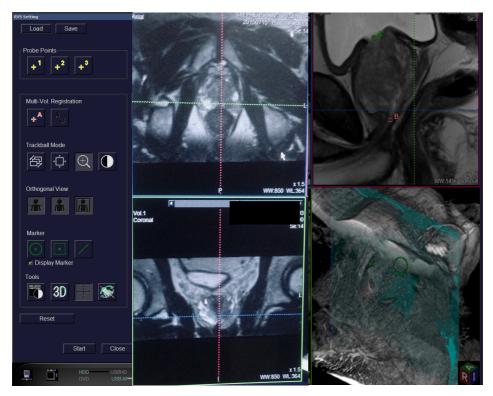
Biopsy planning on T2 SPACE MRI sequence
